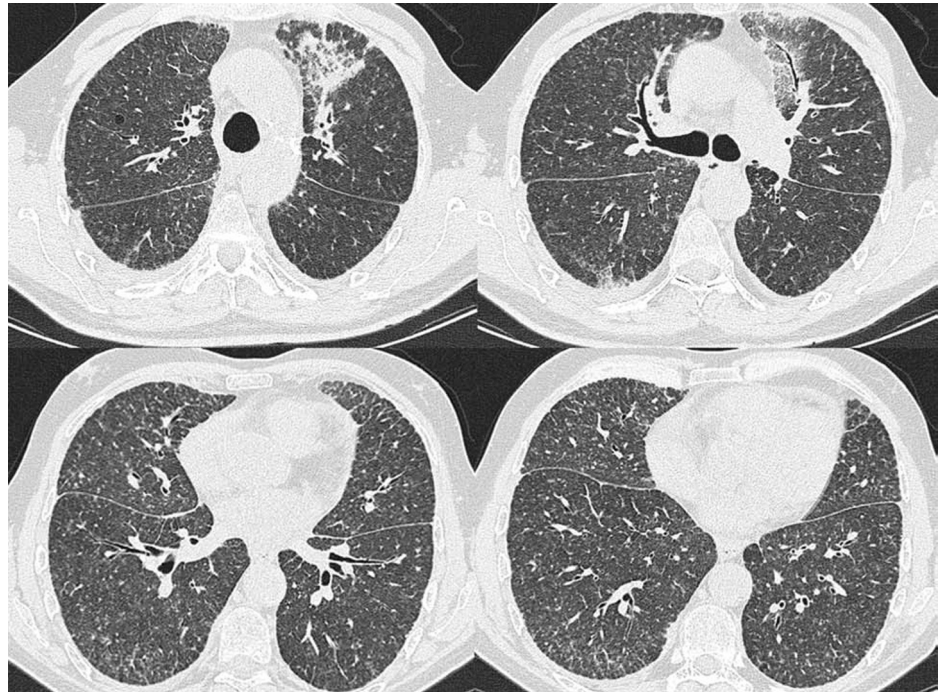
High-resolution computed tomography showing peripheral increase in the vascular markings, septal thickening, diffuse nodular opacities in both lungs, and ground-glass opacities in the left lung.
